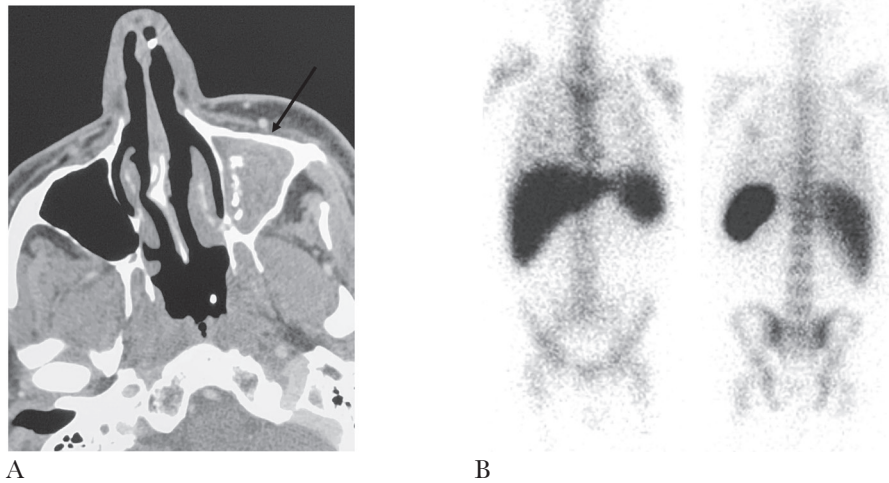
FP and FN in the same patient. Patient on ventilator, unable to communicate. A, Sinus CT on the day of tracer injection for WBCS showed severe maxillary sinusitis (arrow), suggesting fungal infection, on the left side, perfectly normal on right. B, WBCS shows mild uptake focally on right side (arrow), unremarkable on the left. Thus, the WBCS was FP on the right side and FN on the left. ENT drained the left maxilla a few days later, which showed a mixed bacterial/fungal infection. Abbreviations: CT, computed tomography; ENT, ear, nose, and throat specialist; FP, false-positive; FN, false-negative; WBCS, white blood cell scintigraphy.
